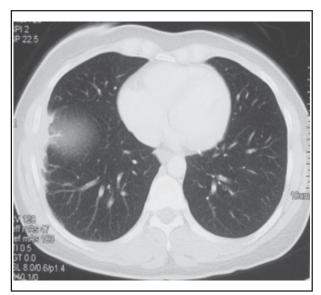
Thorax spiral CT revealing pleural involvement at right lung.
